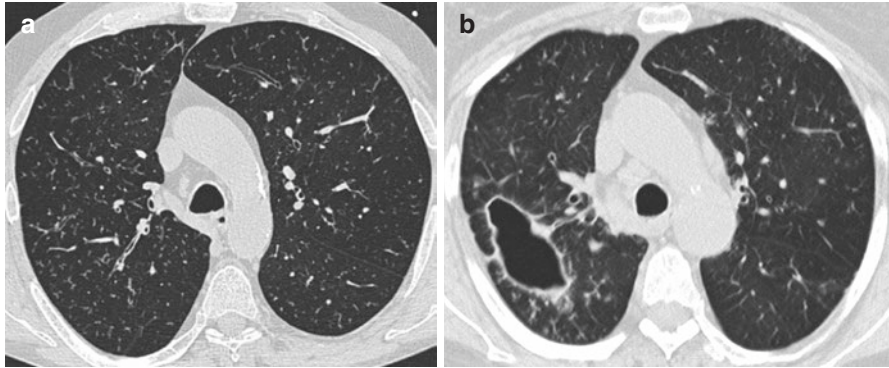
Nontuberculous mycobacterial infection in two patients being treated with TNFi therapy. (a) Axial HRCT image in a RA patient demonstrating tree-in-bud-type opacities throughout both lungs consistent with exudative bronchiolitis seen in nontuberculous mycobacterial infection. (b) Axial HRCT image in a RA patient with a large cavitation lesion with surrounding demonstrating tree-in-bud-type opacities indicating the presence of exudative bronchiolitis. Nodules with cavitation and tree-in-bud opacification are HRCT features of nontuberculous mycobacterial infection
